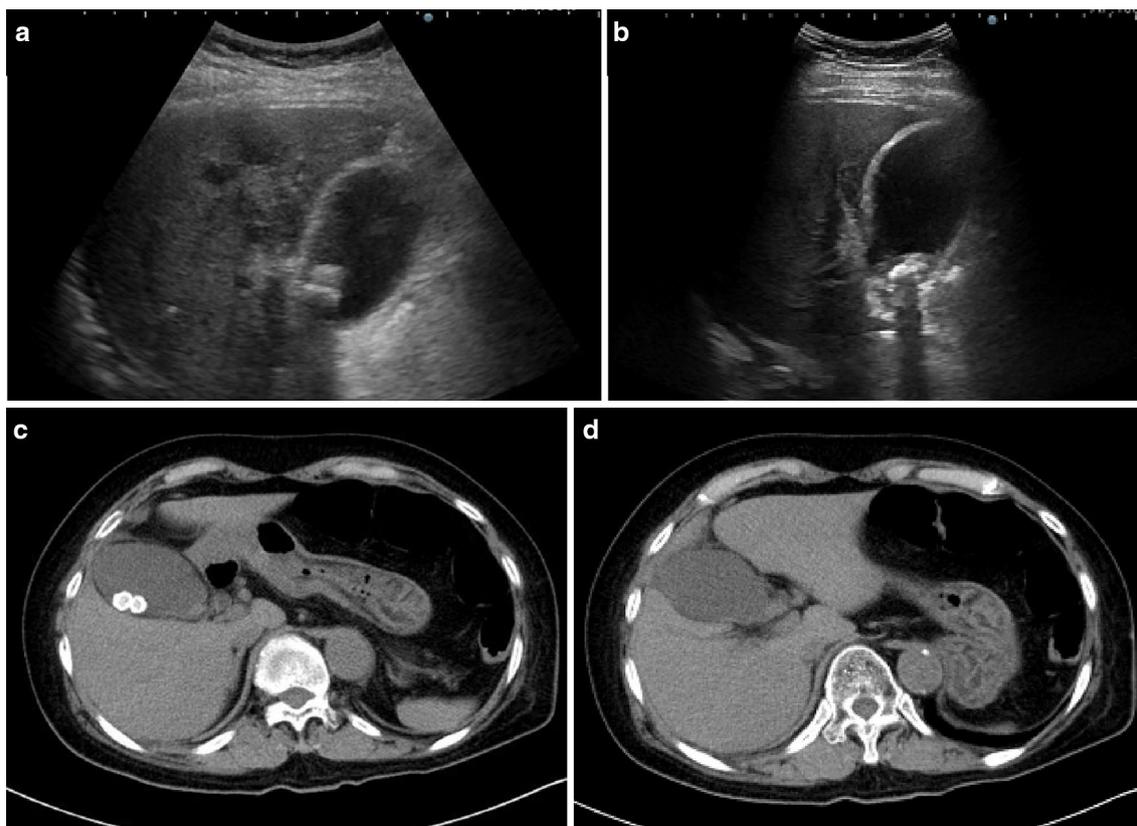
Preoperative images showing acute cholecystitis with gallstones. a, b Abdominal ultrasonography and c, d computed tomography images showing a slight thickened gallbladder wall and two calculi
